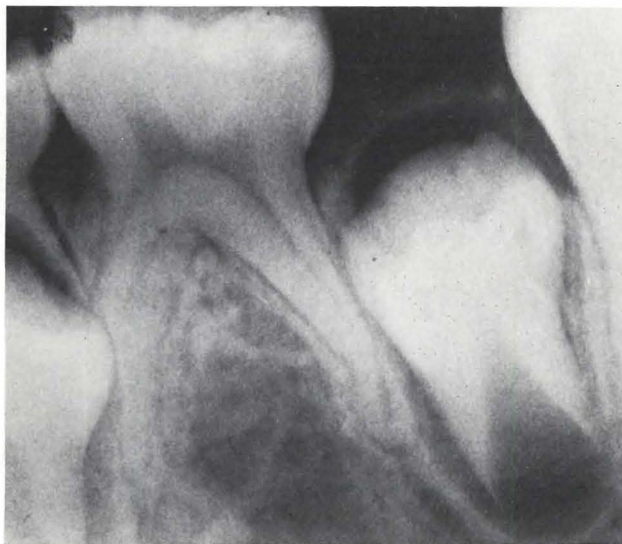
Intraoral radiograph showing the transposed position of the mandibular second premolar.
